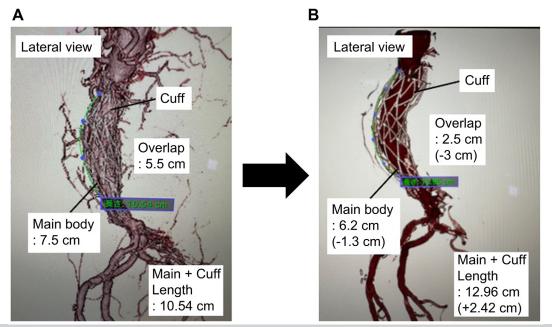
Three-dimensional computed tomography lateral view of patient 2. A, Postoperative day 3. B, Four years later.
